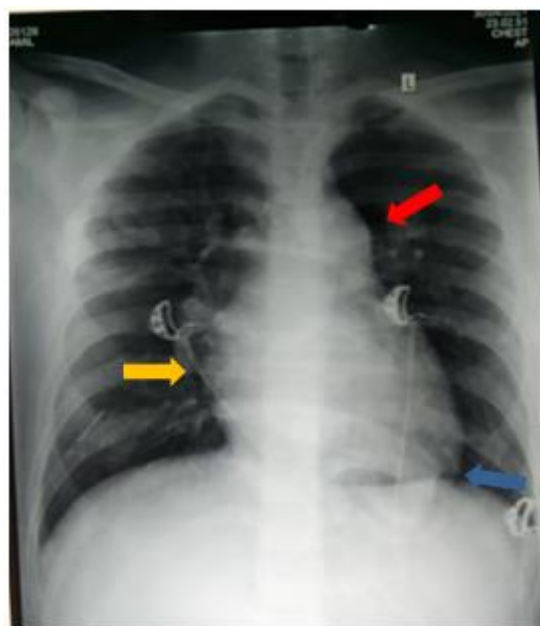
Chest X-ray showed cardiomegaly with bulging main pulmonary segment that makes flatten cardiac waist (red arrow), right heart border enlargement (yellow arrow), and upward apex (blue arrow).
